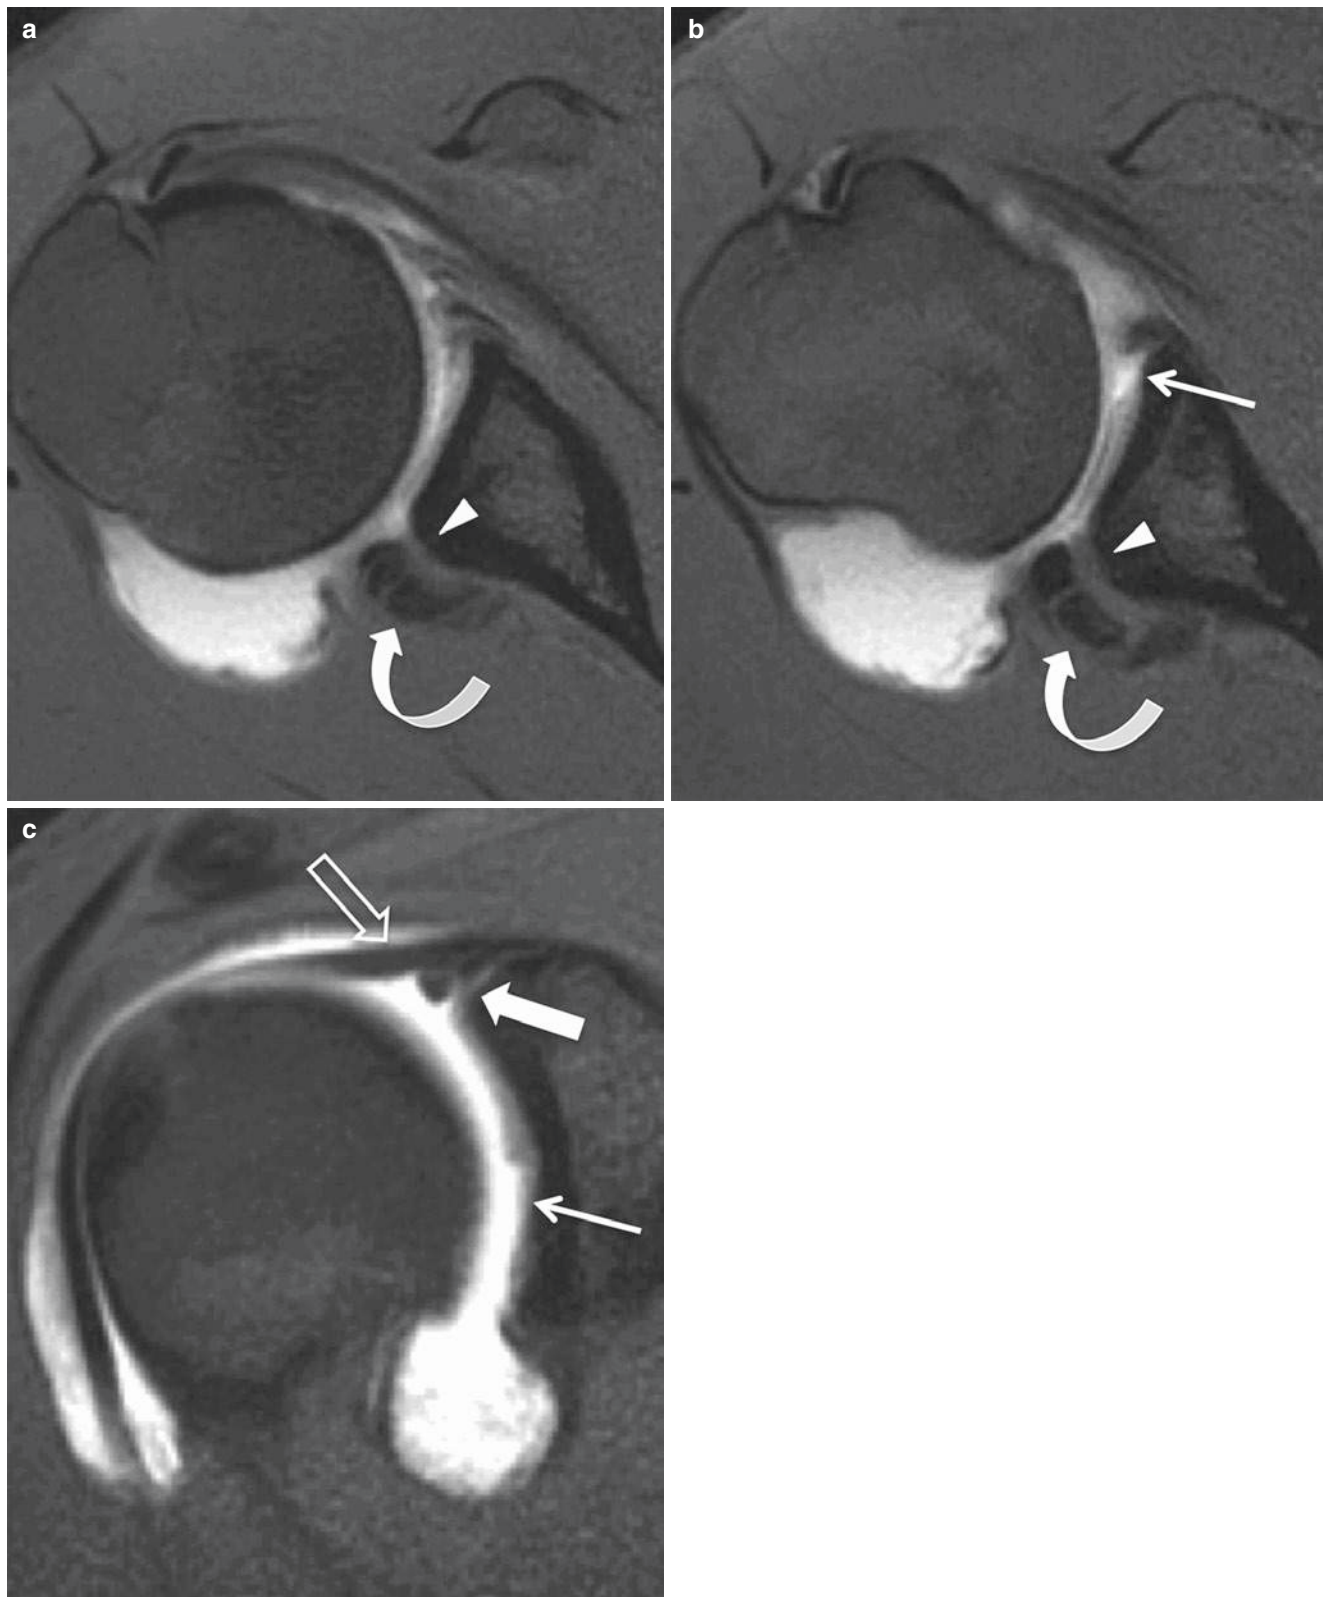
Acquired multidirectional microinstability in a hockey player with history of symptomatic subluxation. Axial (a and b) and coronal (c) fat suppressed T1-weighted MR arthrographic images show a displaced fracture of the posteroinferior glenoid involving the adjacent labrum (*curved arrow*) consistent with a reverse osseous Bankart
